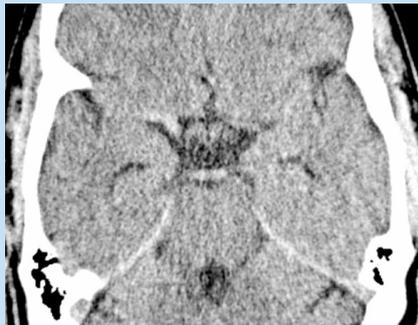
Axial unenhanced CT scan showing the hyperdense appearance of the terminal right ICA and proximal MCA.
